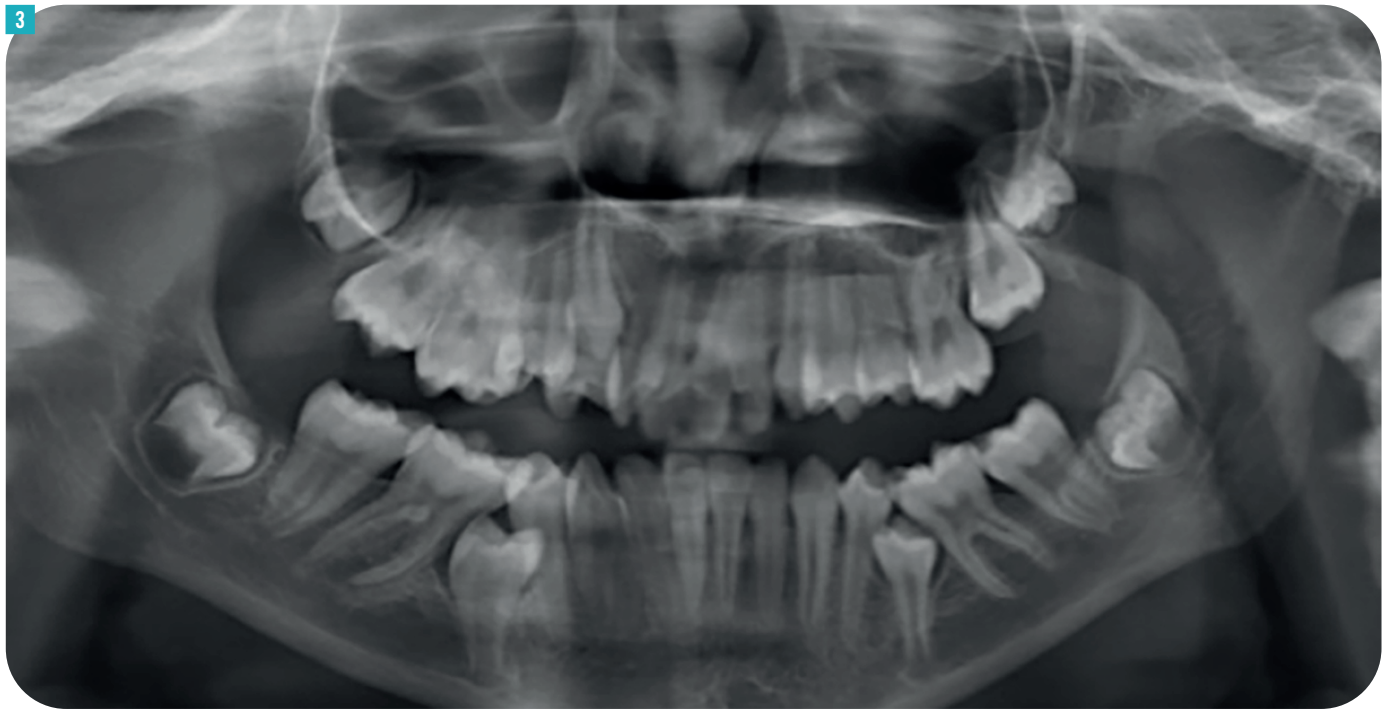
OPG X-ray showing impacted LR5 and LL5 due to severe crowding
